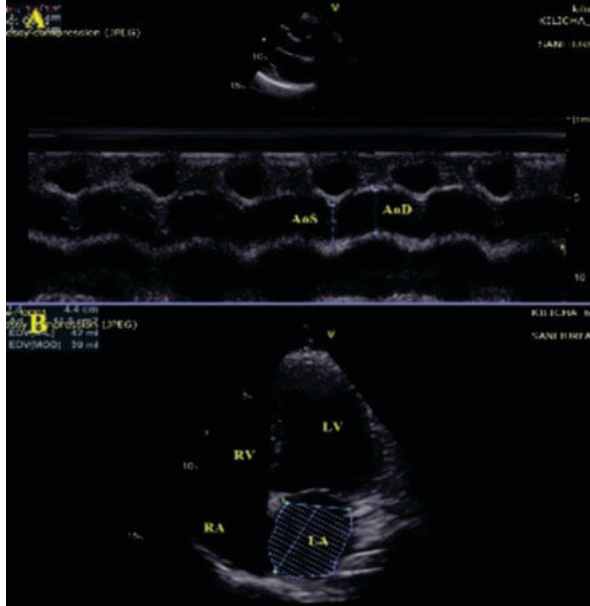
AoD and AoS measurements from parasternal long axis view (A) and LAV calculation from apical 4-chamber view (B).
